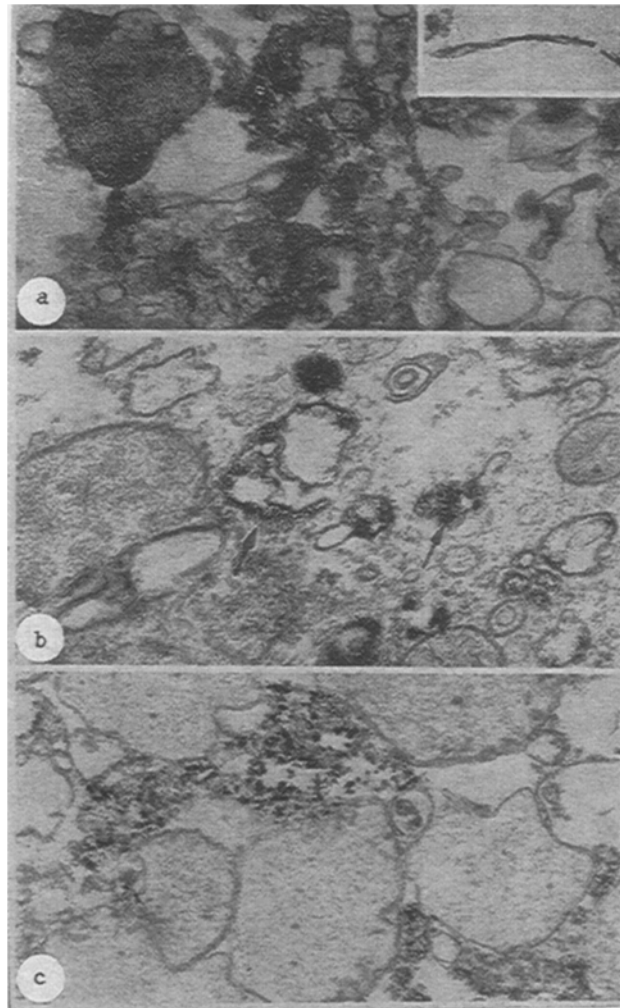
Lesions of hepatocytes 5-7 sec after incision made with ultrasonic destructor. a) Zone of inactivation. Cell debris consists of vesicles of different sizes and electron density, severely damaged peroxysomes and mitochondria, and also single fragments of deformed membranes (insert), 82,200 $\times$ ; b) proximal region of transition zone. Vesiculation of SER and RER, edema of mitochondria and peroxysomes. Diffusion of products of reaction for GP in cytosol (arrow). 82,200 $\times$ . c) In some hepatocytes marked widening of cisterns of SER and RER can be seen. Precipitates of cerium phosphate have the appearance of tiny granules. 30,200 $\times$ .
